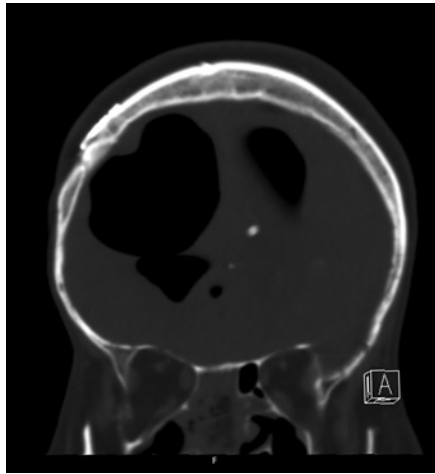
Preoperative computed tomography (CT) image showing diffuse pneumocephalus of basilar cisterns and lateral ventricles.
